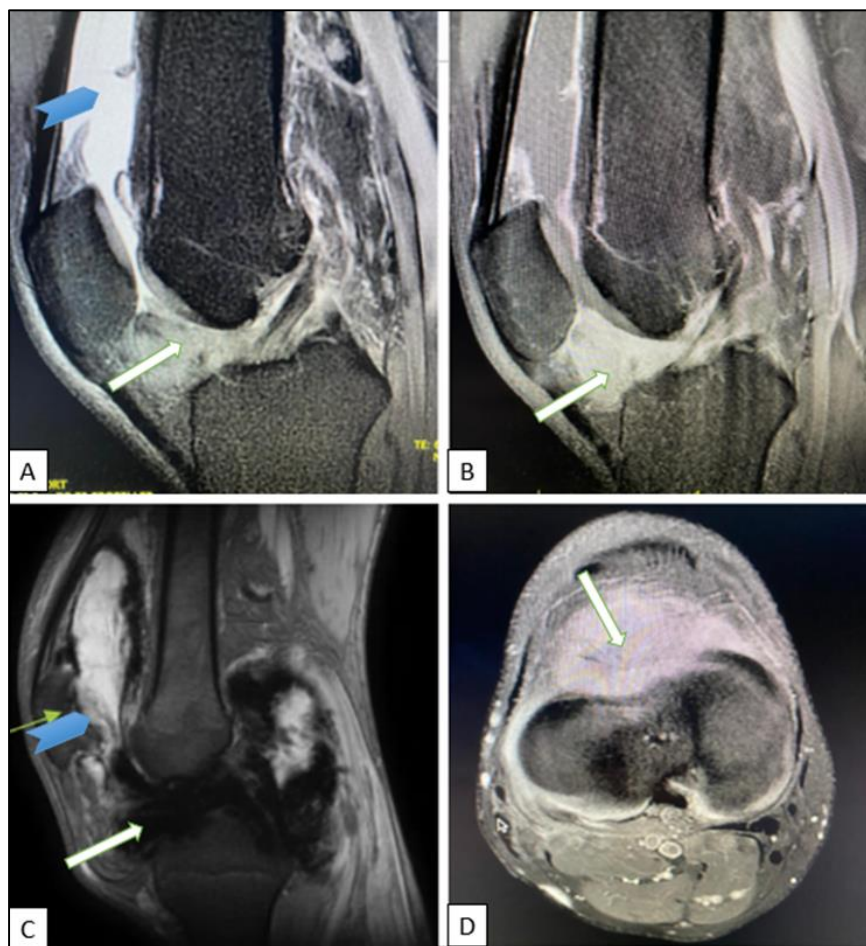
MRI of the right knee in sagittal T2 (A), T2 EG (C), and sagittal (B) and axial (D) gadolinium injection weighted sequences, showing an intra-articular effusion (blue arrow) in hyposignal T1, intermediate signal T2 with empty areas of signal better visible in T2 EG evoking hemosiderin deposits, with lesion enhancement (white arrow)
